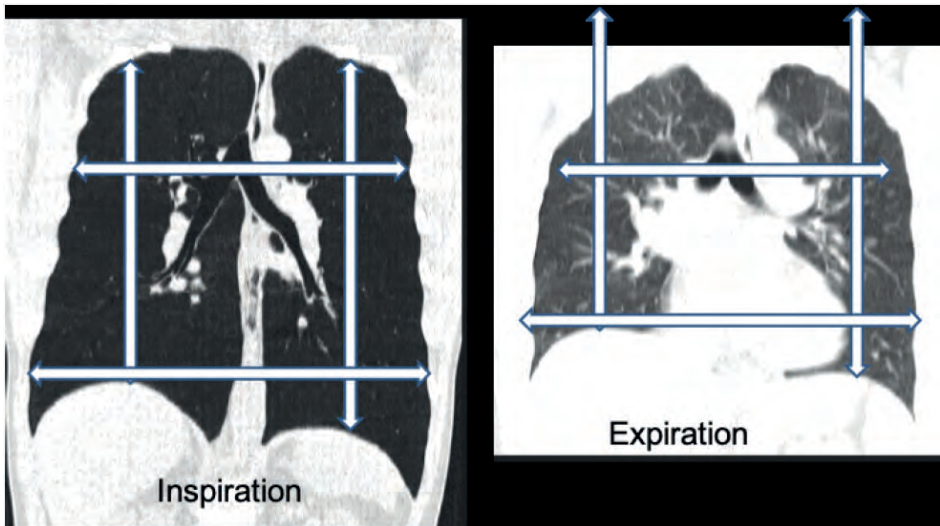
Lung volume on computed tomography at total lung capacity and after full expiration
